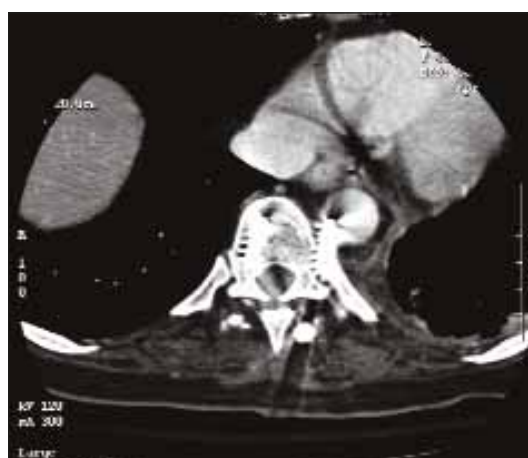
CT scan shows the left lateral interpedicular screws protruding into the posterolateral aspect of the aortic lumen at the T12-L1 level. Although periaortic hematoma is not visualized, penetration into the lumen cannot be excluded.
